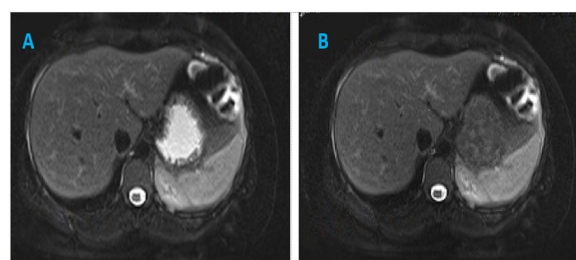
MRI transverse slice of the abdomen (T2-weighted) during imaging circumstances: single-shot fast spin-echo. (A) pre-contrast (B) post-contrast.
